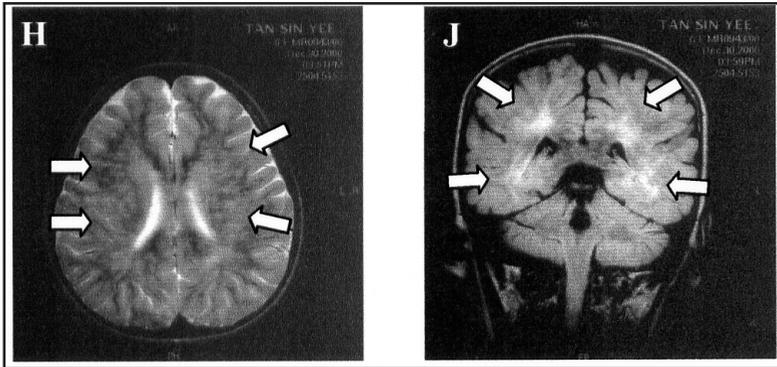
(Case 4): Magnetic resonance T2 weighted axial (H) and coronal FLAIR (J) sequence images showing diffuse hyperintense signals throughout the white matter of the cerebral cortex and cerebellum (white arrows).
